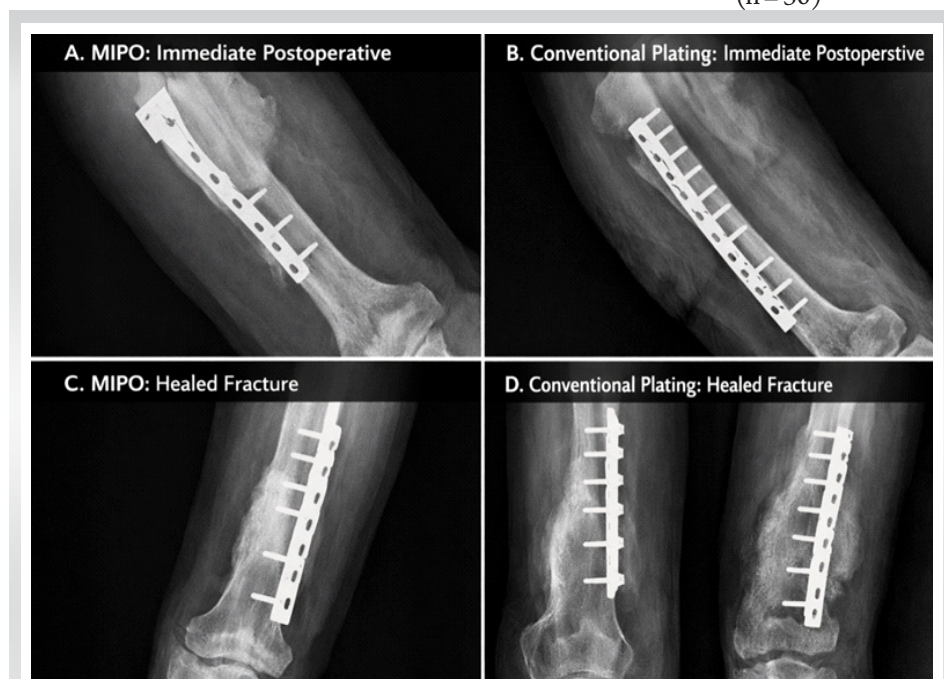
Radiographs of clinical cases comparing the two methods.
